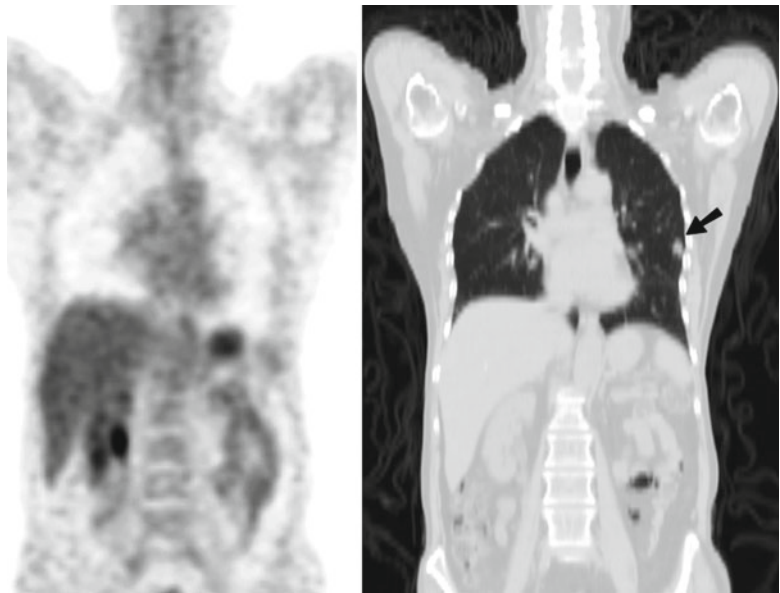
Coronal PET (*Left*) and CT (*Right*) images of a 58-year-old woman who presented for further characterisation of an irregular 10 mm solitary pulmonary nodule in the lower lobe of the left lung (*arrow*). The lesion had faint FDG uptake on PET with an SUV_{max} of 1.1. The patient underwent surgery, and a T1N0 bronchoalveolar carcinoma was removed
